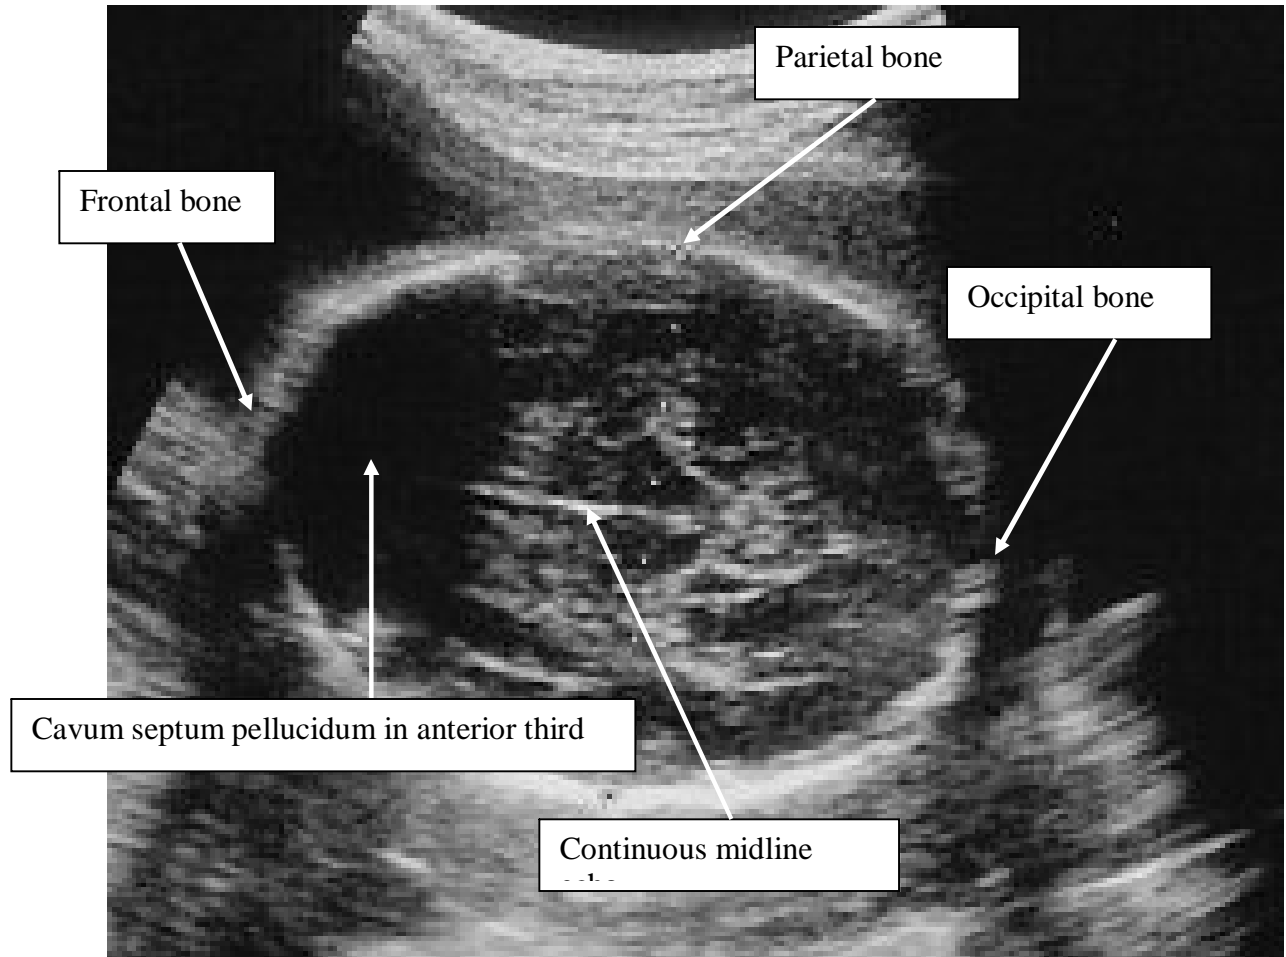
A picture of a transverse section through a fetal skull taken during one of the ultrasound examination sessions. Fetal head measurements were made in an axial plane at the level where the continuous midline echo is broken by the cavum septum pellucidum in the anterior third and that includes the thalamus
